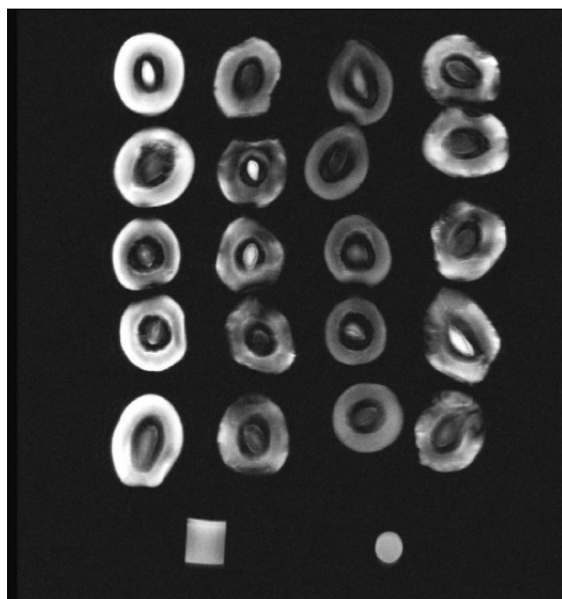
MR fat suppression images for all varieties with 5 replica; *Mega* is first column at the left, *Light* is second column at the left, *Ayvalik* is second column at the right, *Sele* is first column at the right. Above the MR image, there are two reference samples to increase signal to noise ratio.
